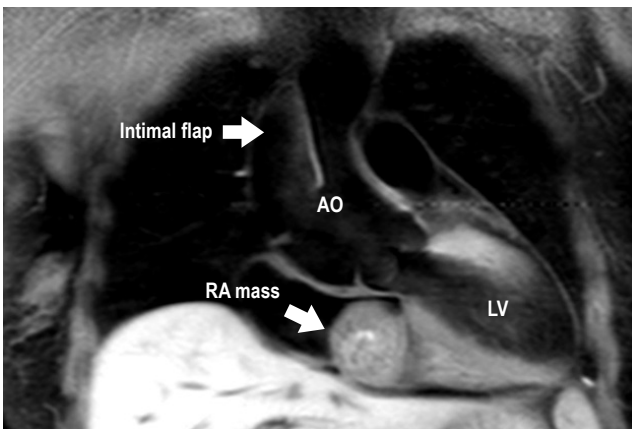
T1-weighted dark blood image with fat suppression showed brightness persisting on fat saturated image, excluding fat-originating tumor. Aneurysmal change and dissection (intimal flap) of the ascending thoracic aorta.
